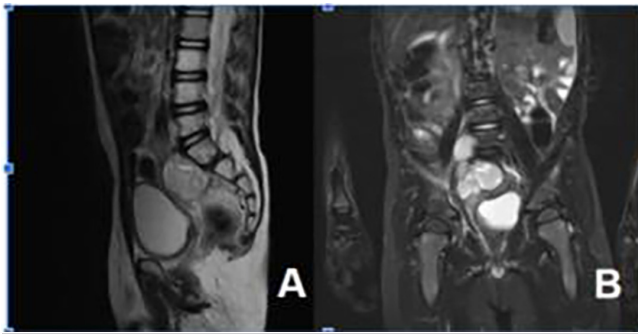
A. Preoperative MRI of the retroperitoneal mass near the iliac vessels and rectum. B. Postoperative MRI confirming residual tumor progression in the distal right psoas muscle and recurrence near iliac structures.
